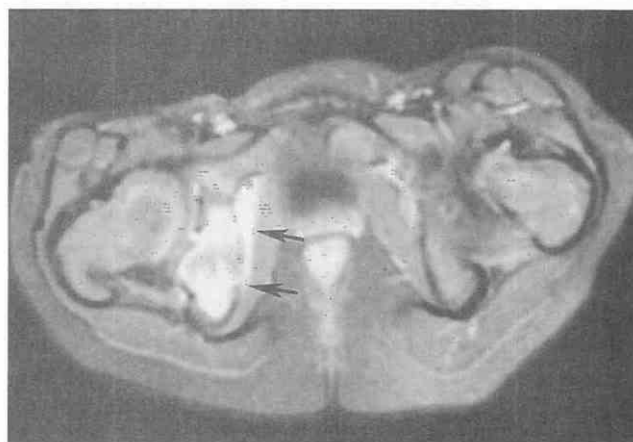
Focal Langerhans' cell histiocytosis of the right ischium in a 3-year-old girl. Postgadolinium axial T1-weighted image (TR = 600 msec, TE = 18 msec) with fat saturation shows marked, but slightly inhomogeneous, enhancement within the lesion (*arrows*). The medial ischial cortex is destroyed.
